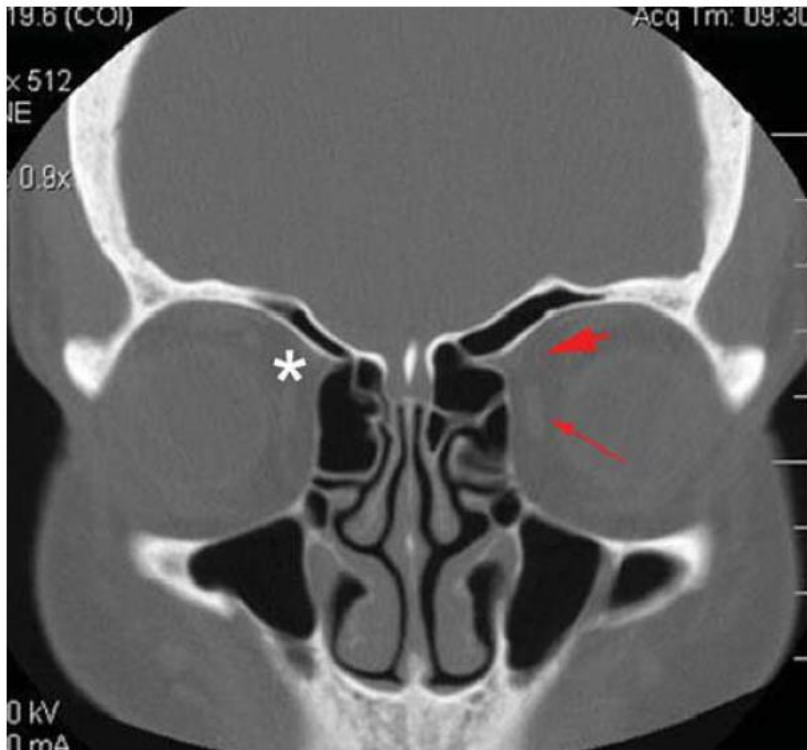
A coronal CT of the paranasal sinuses featuring the location of the anterior ethmoidal artery (*asterisk*) near the convergence of the medial rectus (*arrow*) and superior oblique (*arrow-head*) muscles. Note that in this patient, the anterior ethmoidal artery (*asterisk*) is located within a bony mesentery, suspended from the skull base.
